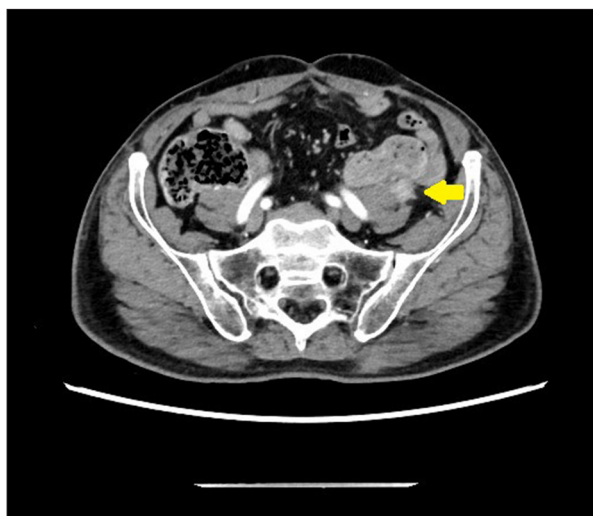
A 77-year-old man with a pulse granuloma of the descending colon. An abdominal contrast-enhanced computed tomography (CT) scan showing an irregular nodule on the dorsolateral side of the descending colon (arrow).
